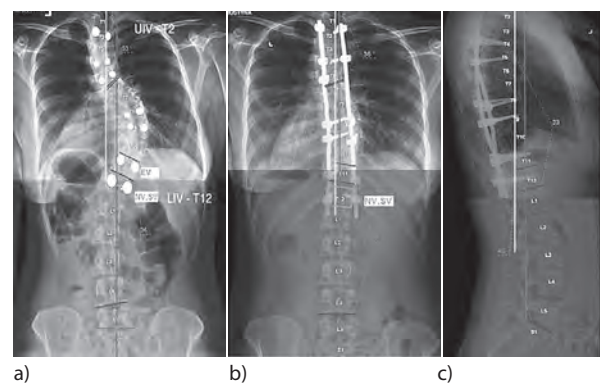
a) Correct identification of fusion levels, the Lowest Instrumented Vertebra (LIV) and the Upper Instrumented Vertebra (UIV) of our planned fusion, b,c) postoperative standing PA and lateral radiographs
